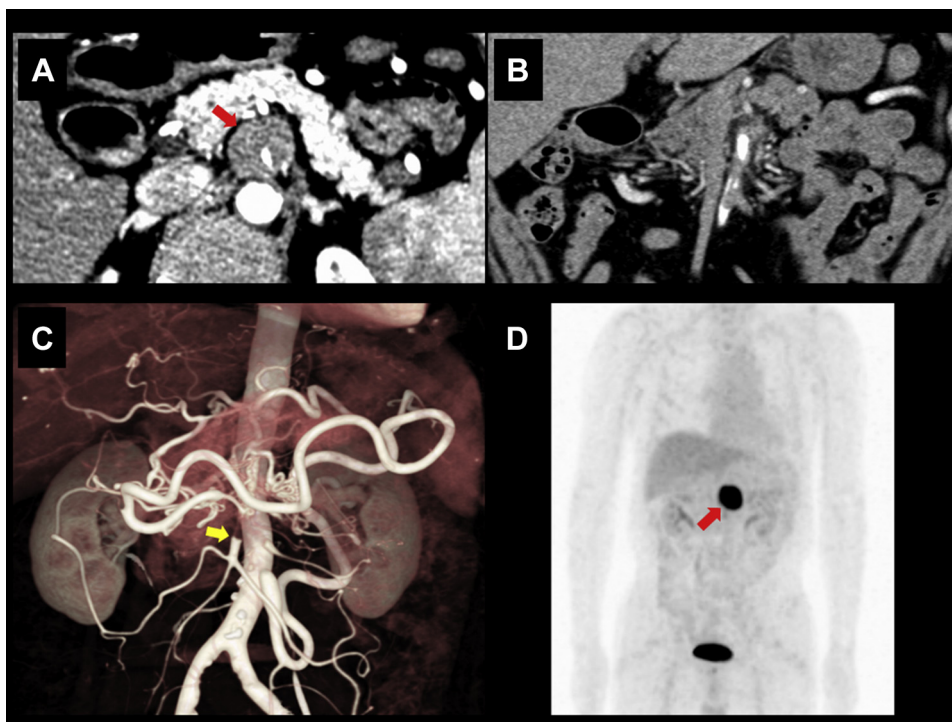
Preoperative computed tomography images. The *red arrows* indicate a round mass centered into the superior mesenteric artery (SMA). A, Axial image demonstrating a mass centered within an SMA with wall enhancement. B, Coronal image demonstrating a partial filling defect in the distal SMA. C, Three-dimensional computed tomography angiography (CTA). The SMA was occluded to the range indicated by a *yellow arrow*. D, ¹⁸F- fluorodeoxyglucose (FDG) positron emission tomography/computed tomography on coronal images. FDG uptake (a maximal standardized uptake value = 28.5) was shown, suggestive of a malignant lesion.
